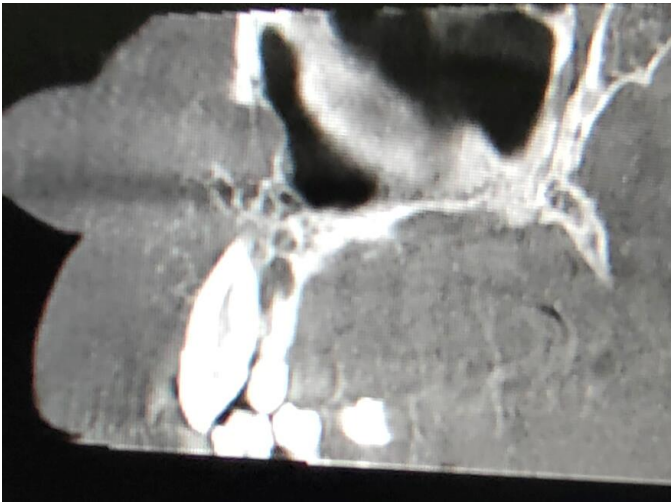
CBCT sagittal view
